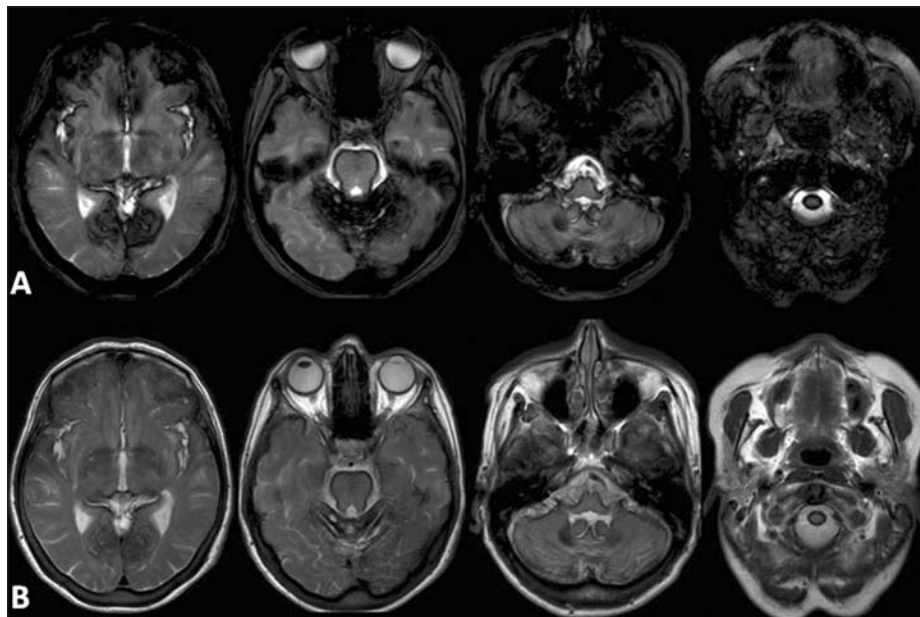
MRI scanner with gradient-echo sequences (A) and axial T2 weighted images (B) showing a low signal intensity rim over the cerebellar vermis and folio, cerebral cortex, brainstem, cranial nerves and cervical spinal cord. Note the maximum hemosiderin deposit at the tentorium level. The gradient echo sequences show more extensive abnormality.
